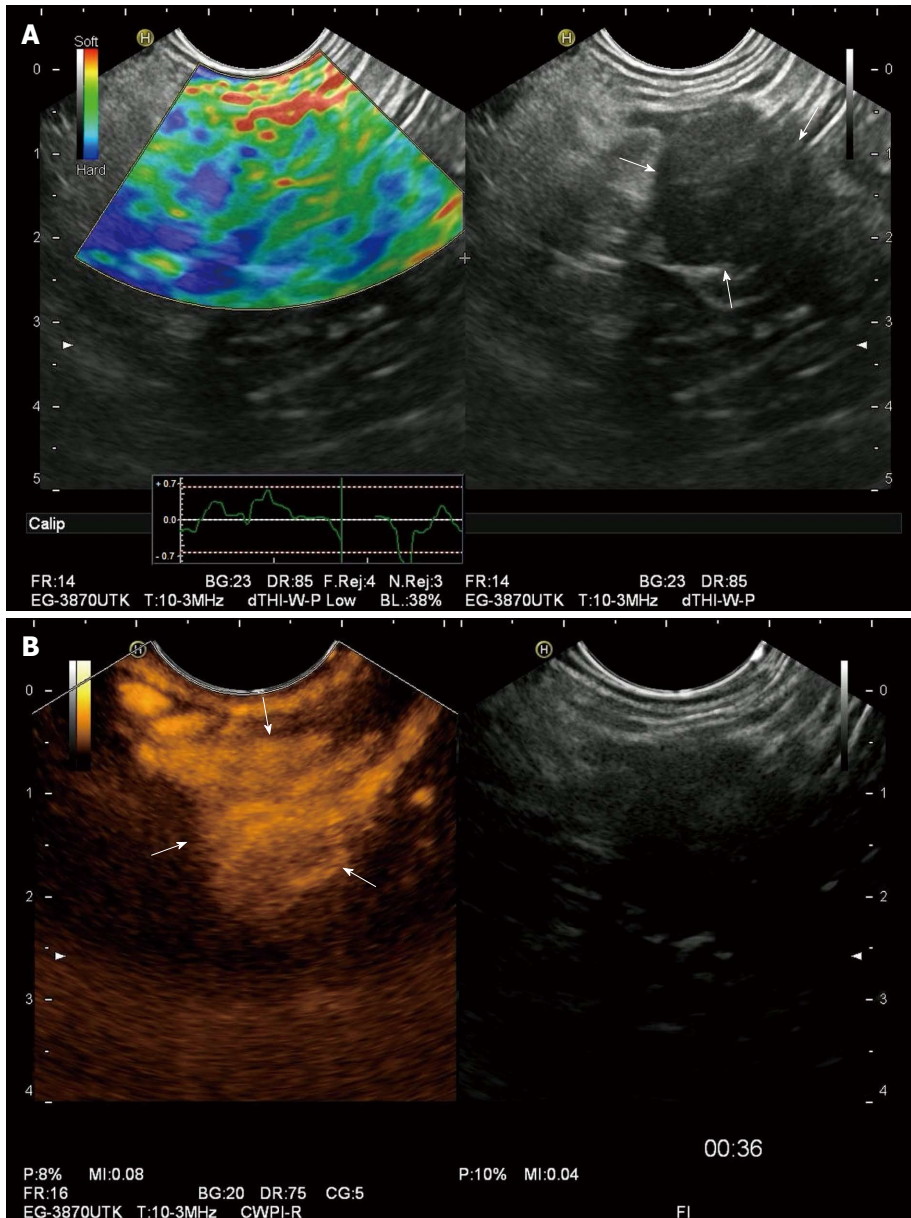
Benign adrenal gland tumor is typically soft (green) on endoscopic ultrasound elastography (A) and hyper-enhancing on contrast-enhanced endoscopic ultrasound (B).
